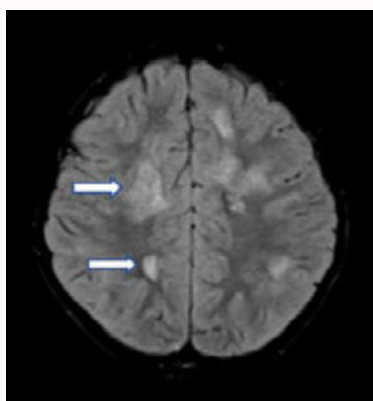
MRI T2/FLAIR image showing hyperintensities in deep white matter of frontoparietal lobes.
